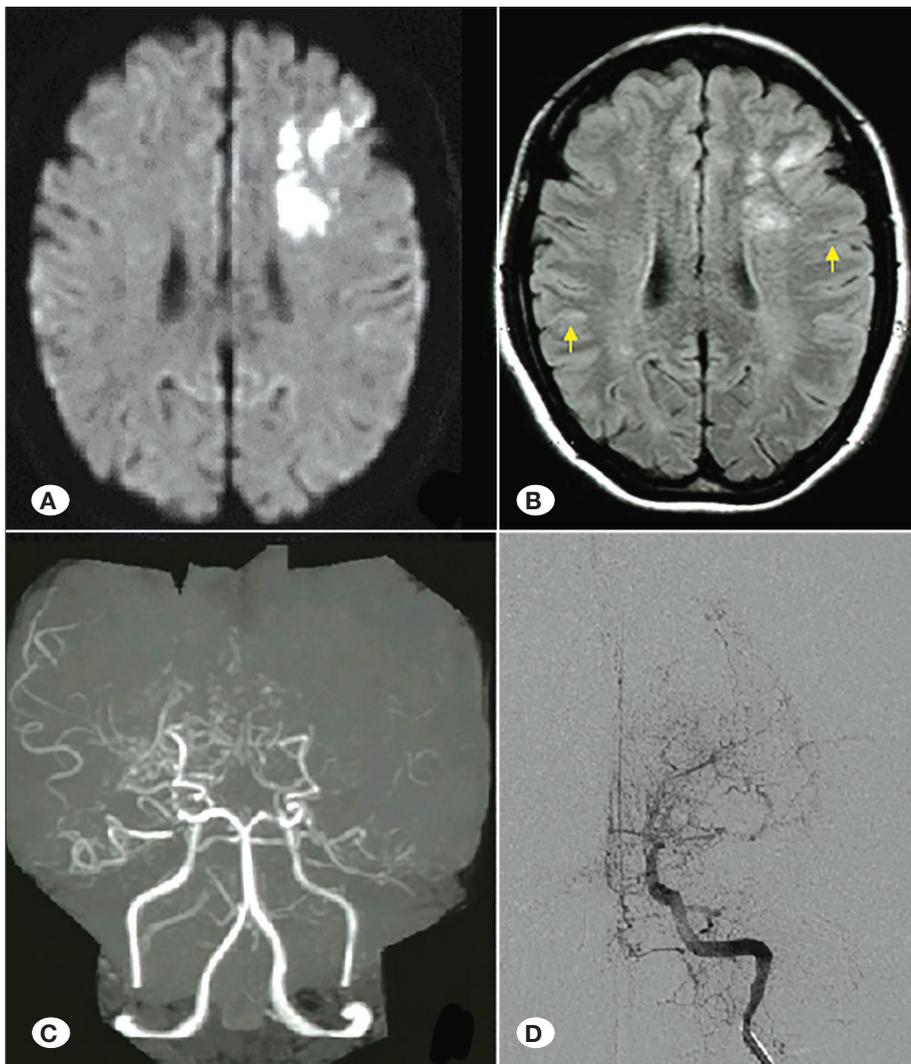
A) MRI-DWI revealed fresh cerebral infarction in left frontal lobe. B) MRI FLAIR images showed the ivy sign. C) MRA revealed bilateral ICA stenosis. D) Typical net-like Moyamoya vessels observed by angiography.
